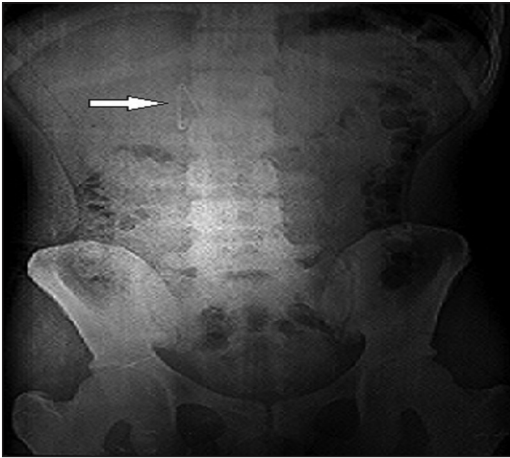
Plain X-ray abdomen showing open safety pin
